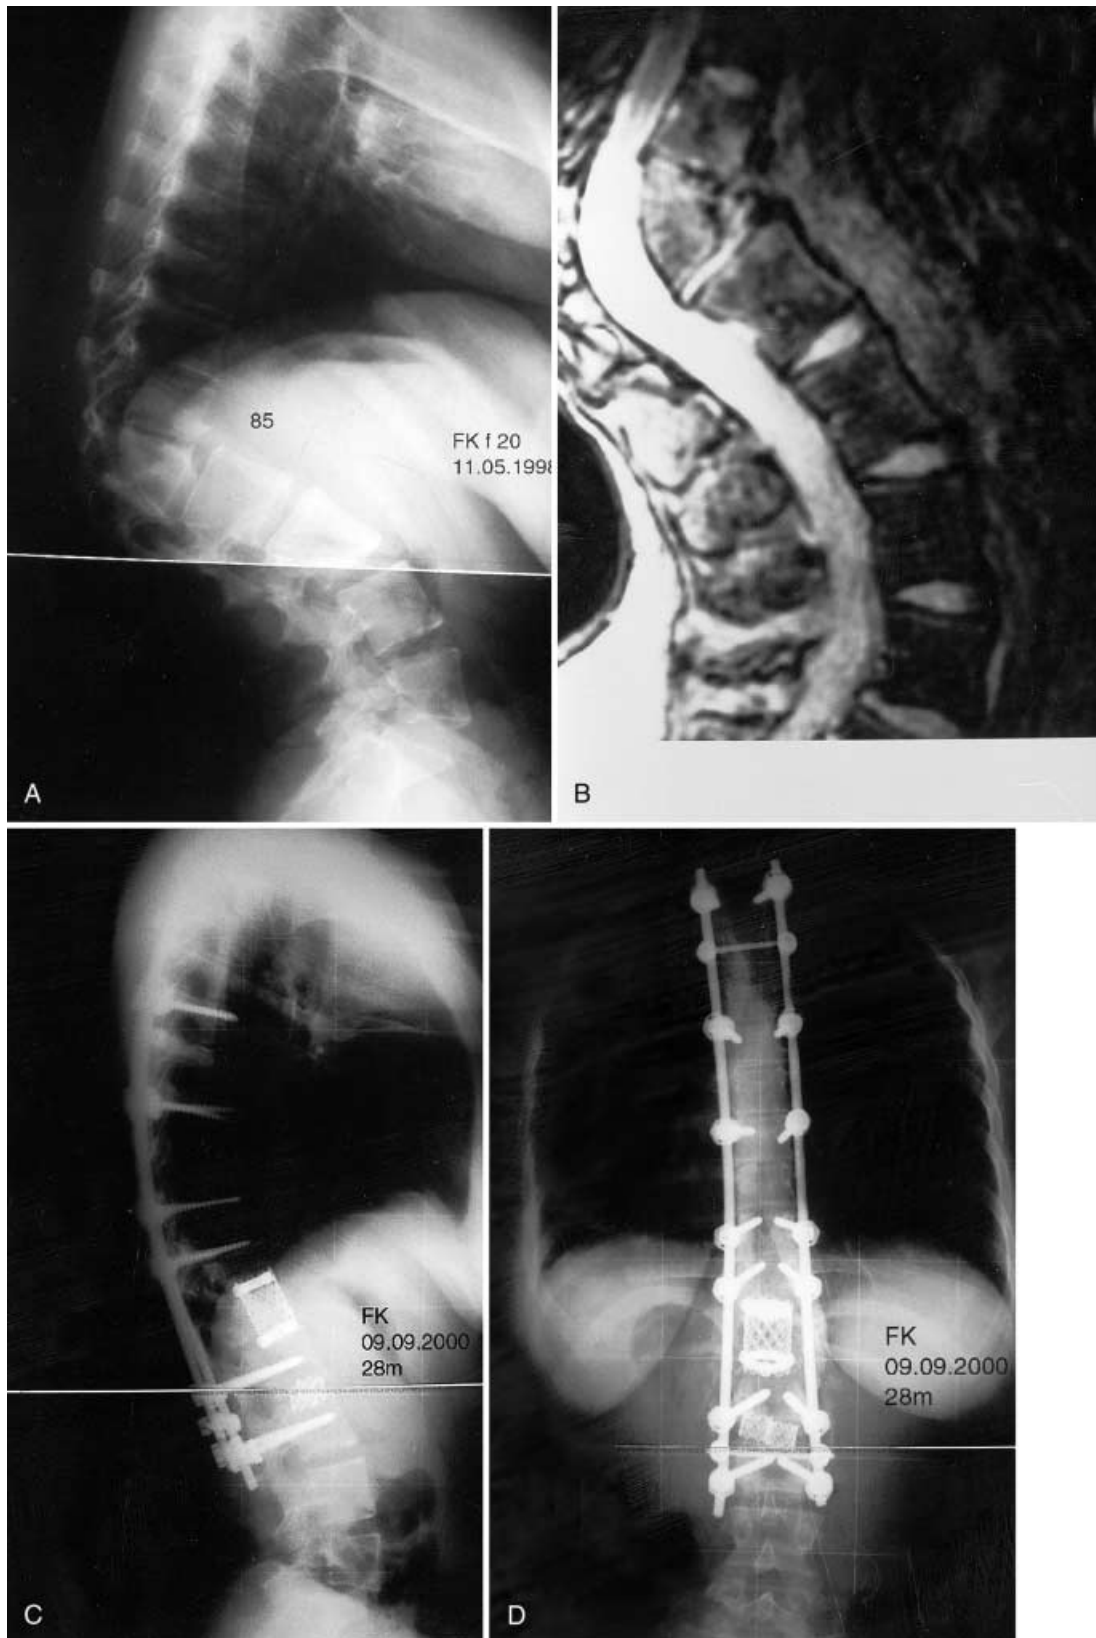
a Preoperative lateral X-ray of patient no. 5 with an 85° kyphosis. b Preoperative magnetic resonance imaging (MRI) of the same patient in the sagittal plane. c,d Postoperative X-rays at the end of the 28th month with 5° residual kyphosis
